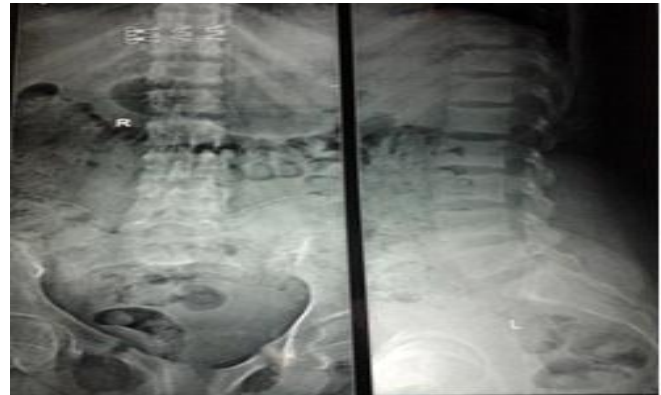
X-Ray pelvis, after three months follow up, showing united fracture in right iliac bone, superior ramus of left pubic bone and both inferior rami of pubic bone and progressively uniting fracture superior ramus of right pubic bone.
